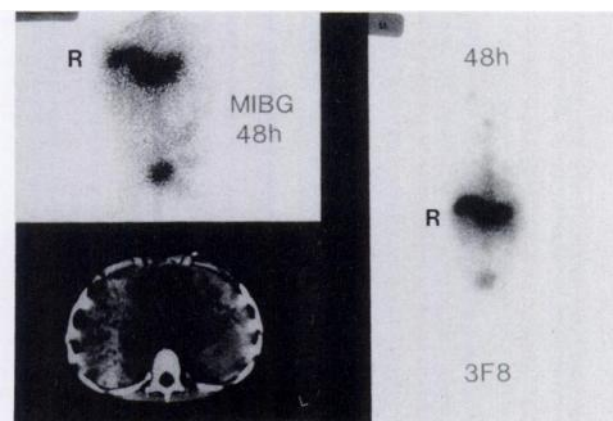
Posterior views of ^{131}I -3F8 and [^{131}I]MIBG scans of Patient 7 showed intense uptake in the superior posterior area of the liver. A large tumor mass was evident in the CT scan. Spine uptake in the vertebral column was seen in the ^{131}I -3F8 images but was less intense in the [^{131}I]MIBG scan.
